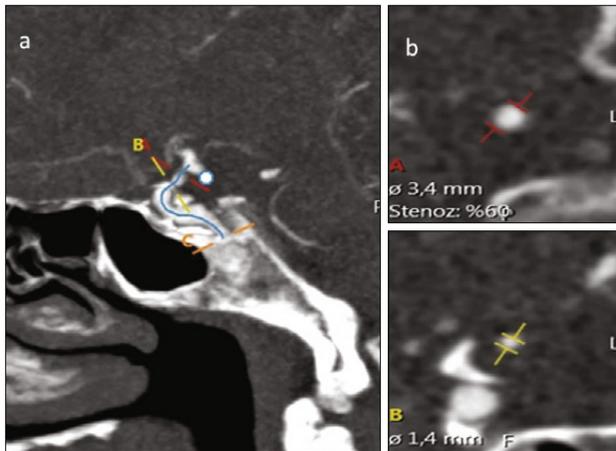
a) CTA shows the stenosis of the supraclinoid (ophthalmic) segment of right ICA, b) significant stenosis can be clearly seen at level B.
